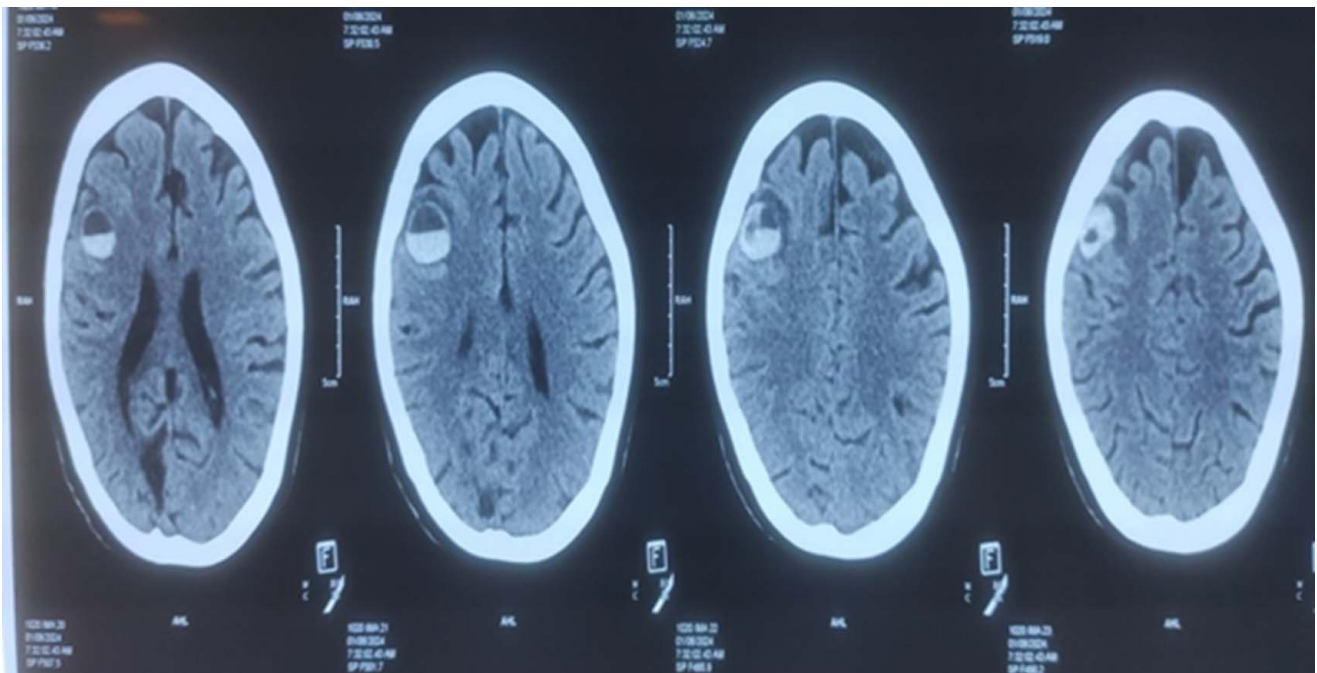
Computed tomography head suggestive of hyperacute parenchymal lobar haemorrhage showing haematocrit effect and measuring 8 cm³ in right frontal lobe with minimal perifocal oedema.
